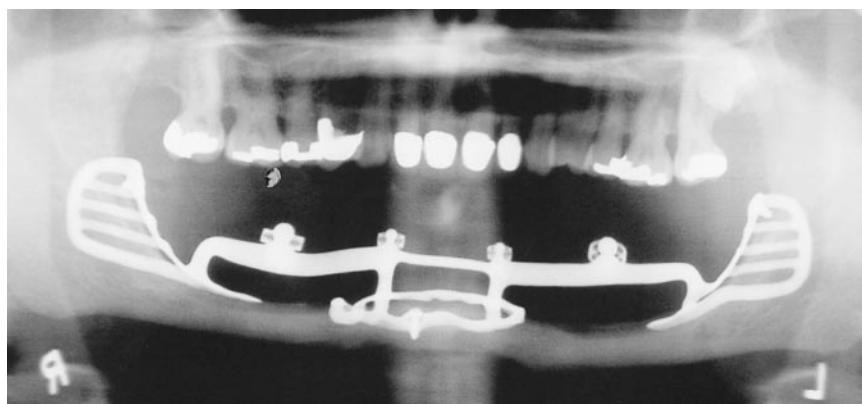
Postoperative panoramic radiograph of the completed subperiosteal implant (dated December 31, 1985).
